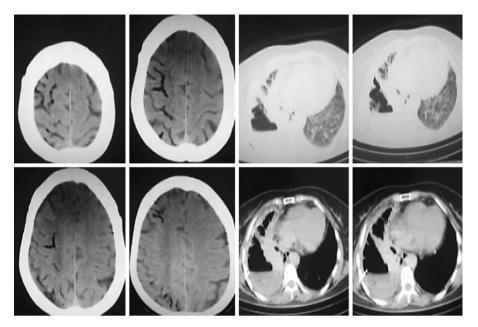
CT of the head and chest at the time of onset.
